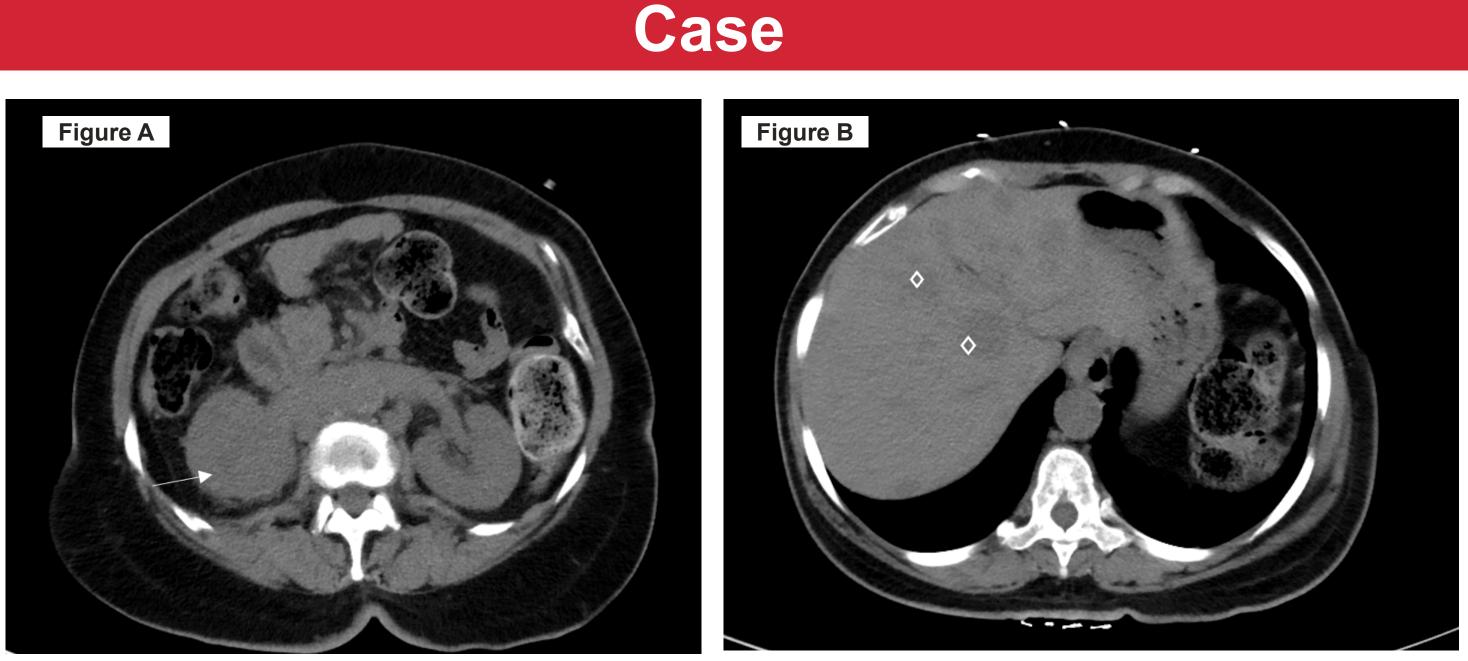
CT Abdomen w/o contrast with arrow pointing to right renal mass with extension into perinephric soft tissue Figure B: CT Abdomen w/o contrast with diamonds pointing to multiple low-attenuation hepatic lesions concerning for metastatic disease
